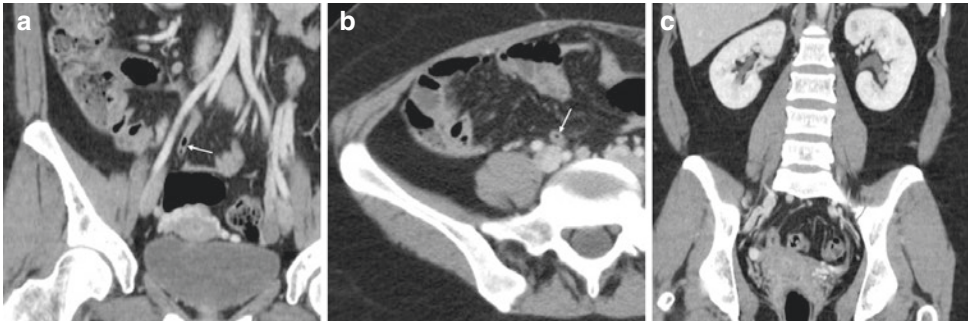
A 34-year-old female suffered from recurrent UTIs after caesarean section a few months earlier. After inconclusive sonography and without previous instrumentation, contrast-enhanced CT showed some air (thin arrows in a, b) in the right ureter, with minimally thickened walls and inhomogeneous perfusion at the upper third of the contralateral kidney (c)
